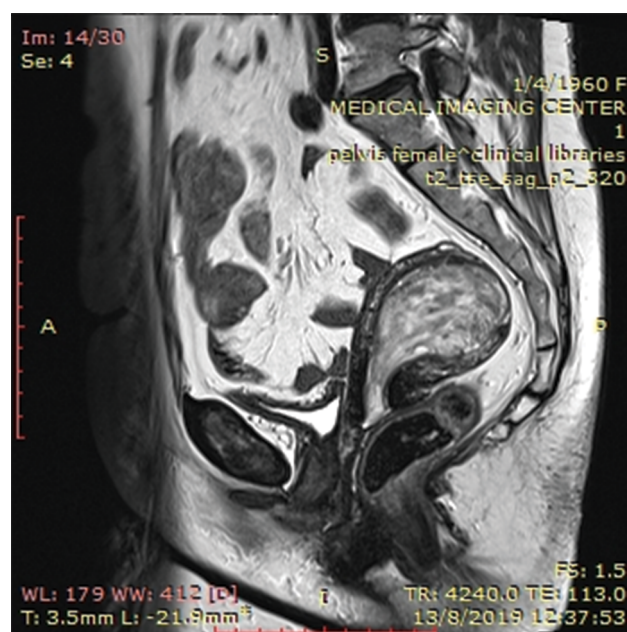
Magnetic resonance imaging revealed the tumour as a lesion of inhomogeneous composition and inhomogeneous contrast enhancement, completely occupying the endometrial cavity
